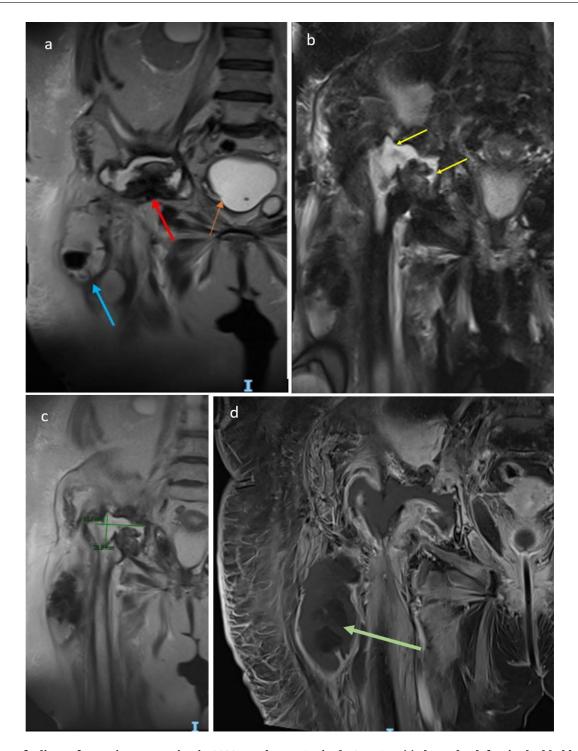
MRI findings of Mrs. F's presentation in 2022 are shown. Sagittal T2 HASTE (a) showed a defect in the bladder (orange arrow) communicating with the fluid tract. The red arrow denotes the periacetabular collection and the blue arrow points to the inferior extent of the third pocket of collection, situated in the proximal anterior thigh with internal calcific material. Coronal STIR (b) and T2 HASTE (c) sequences showed the fluid collection in the vicinity of the right hip measuring 66.7mm by 38.8mm, which was continuous with the defect at the right lateral wall of the bladder.
